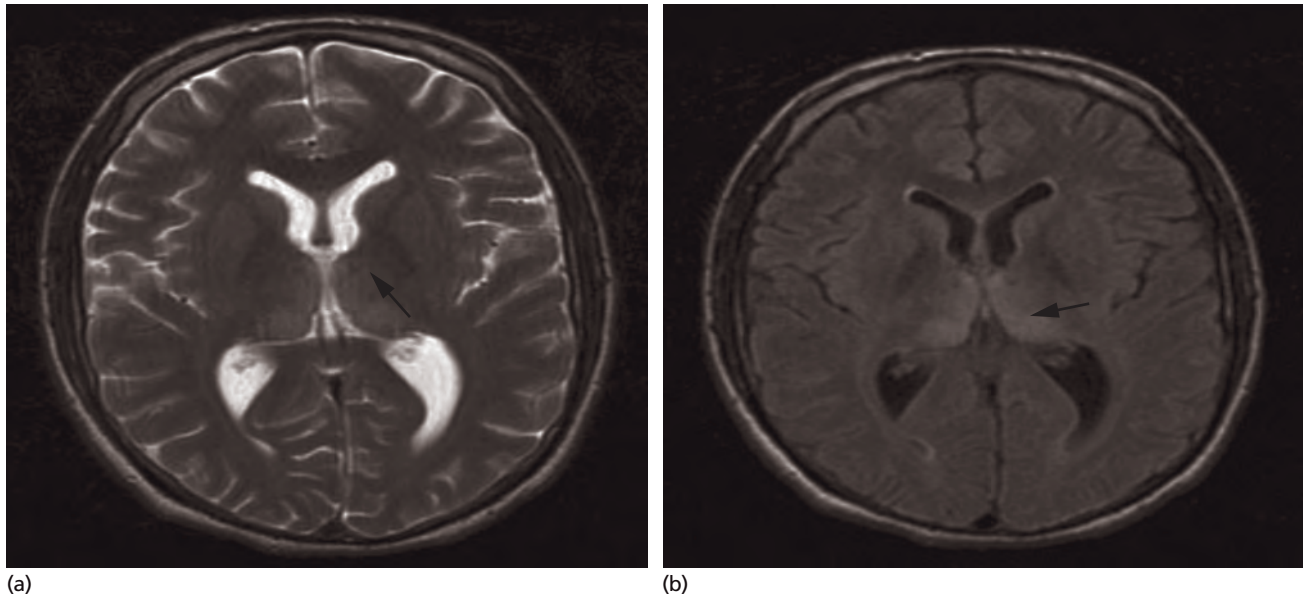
Variant CJD: MRI demonstrates symmetrical increased signal intensity in the pulvinar nuclei bilaterally (pulvinar sign) and dorsomedial thalami on T2 weighted (a) and FLAIR (b) sequences.
